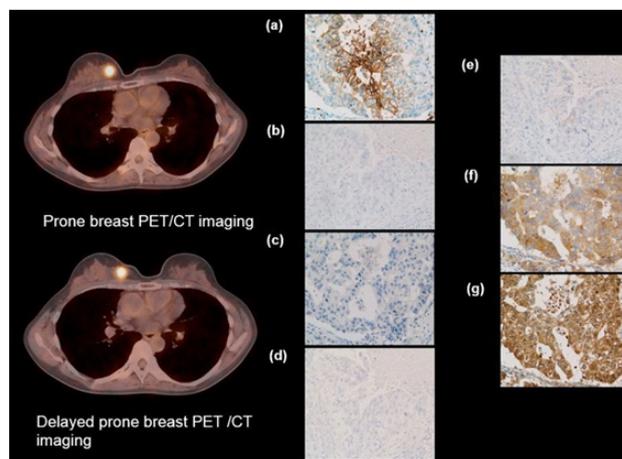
A 53 years old woman with breast cancer (pT1N0M0 stage IA; p-tumor size 15mm, Ng2). The SUV1, SUV2 and RI were 10.1%, 13.8% and 34.92%, respectively. The scores of Glut-1 (a), mTOR (f), and p70S6 (g) expressions were 3, 2 and 2, respectively. The expressions of ER α (b), ER β (c) PR (d), and Her2 (e) were all negative.
